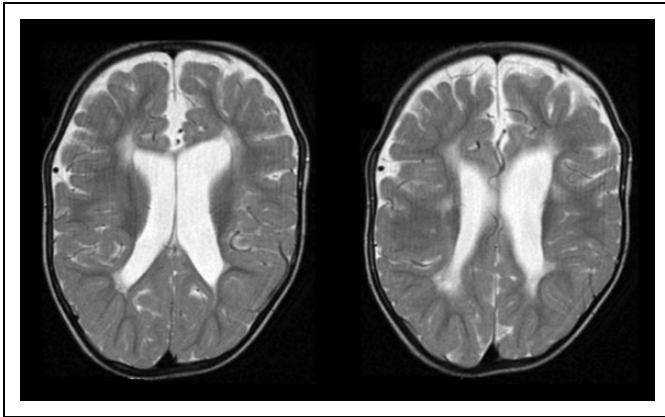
Transversal T2-weight magnetic resonance imaging sections revealing periventricular leukomalacia, mainly anteriorly, and posteriorly seen of both lateral ventricles, suggesting perinatal asphyxia.
